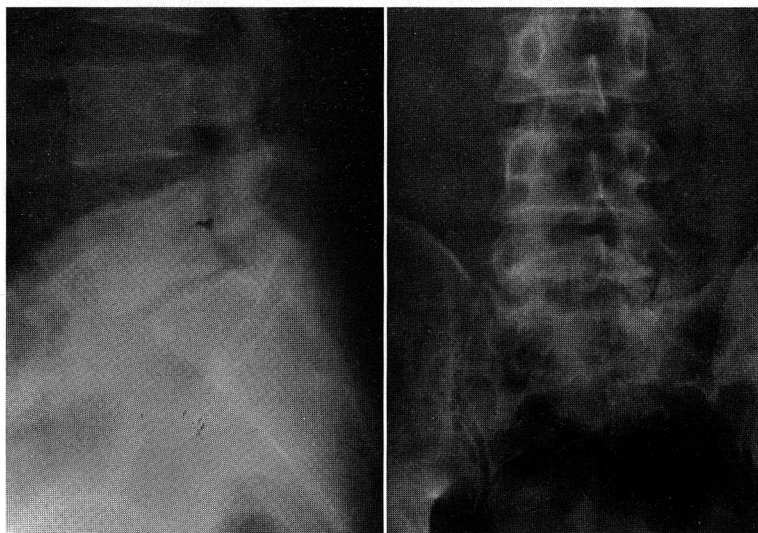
The plain roentgenograms of the lumbosacral spine 15 months after the injury show absorbed L5-S1 disc space and a 20% olisthesis of L5 on the sacrum.
